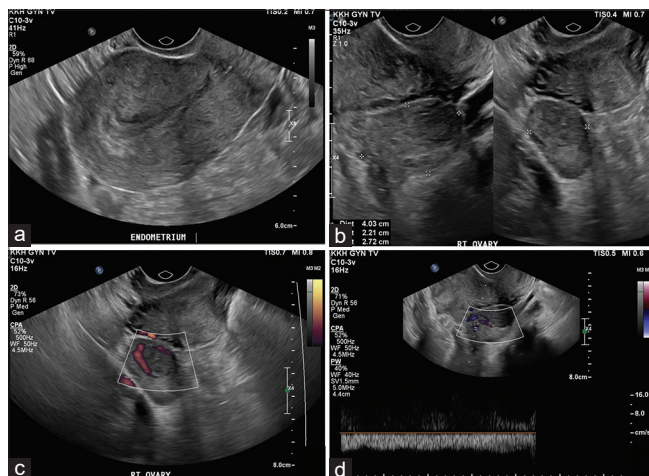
(a) Empty uterus with normal endometrial thickness. (b-d) Normal right ovary with normal Doppler flow
